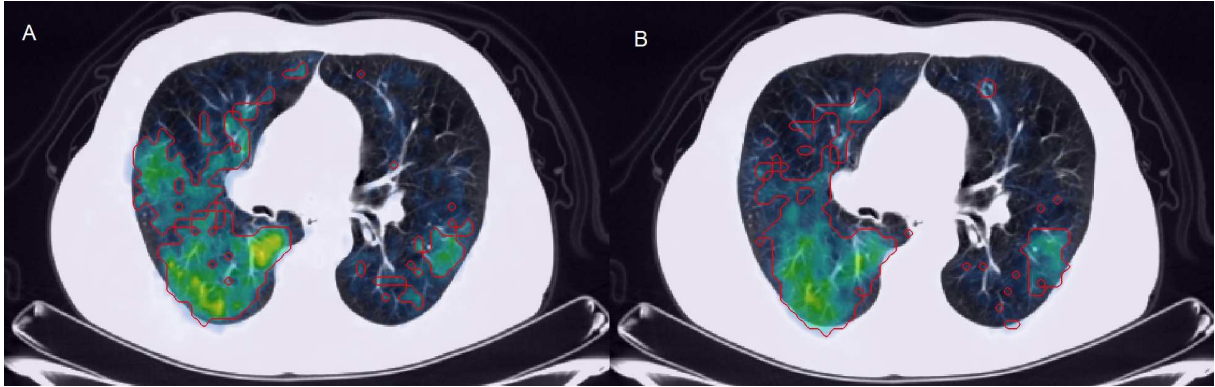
Technegas-SPECT segmentation of ventilated region with a threshold of 31% over the SPECT scan fused with the CT (A). Gallgas-PET segmentation of ventilated region with a threshold of 27% over the PET scan fused with the CT (B).
